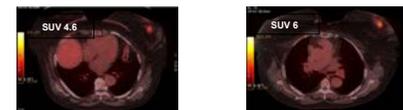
Patient B with increased SUV (SUV 4.6 to SUV 6) after single Bev dose
